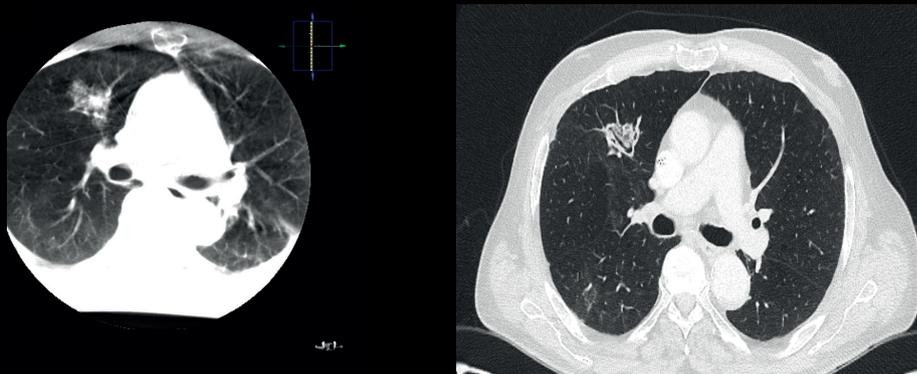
Post ablation cone beam CT to visualize extent of ablation (left). One month post ablation CT showing complete coverage and scarring around the targeted lesion (right)
